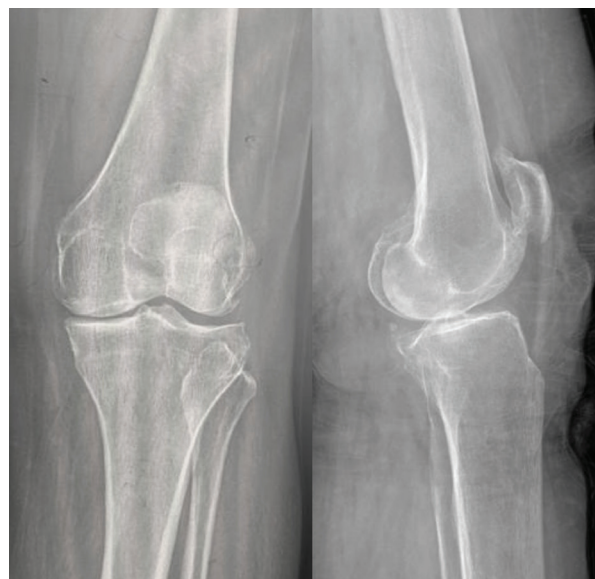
Weight-bearing anteroposterior and lateral knee plain radiographs of a 62-year-old female patient with Kellgren–Lawrence grade 3 knee osteoarthritis
